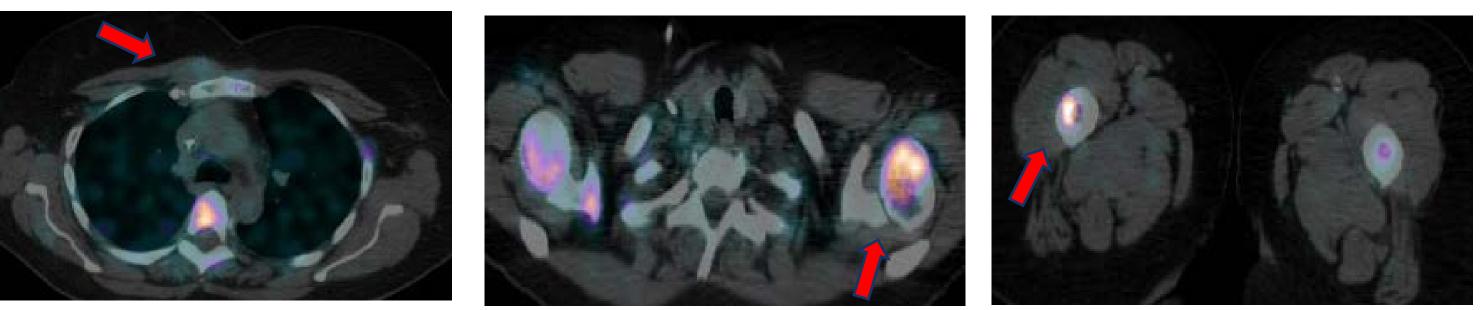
demonstrates follow-up scans (top) and baseline scans (bottom). Patient had extensive bone disease, which is difficult to evaluate on PET scan because CD8+ cells infiltrate the bone marrow. Patient did demonstrate increased CD8+ cell uptake in the sternal soft tissue mass (SUV max percent change +82%), left proximal humerus (SUV max percent change +71%) and right proximal femur (SUV max percent change +23%). No apparent significant change on the contralateral femur or humerus. Patient did not have significant nodal uptake. Patient is currently still on trial with radiographic stability.
